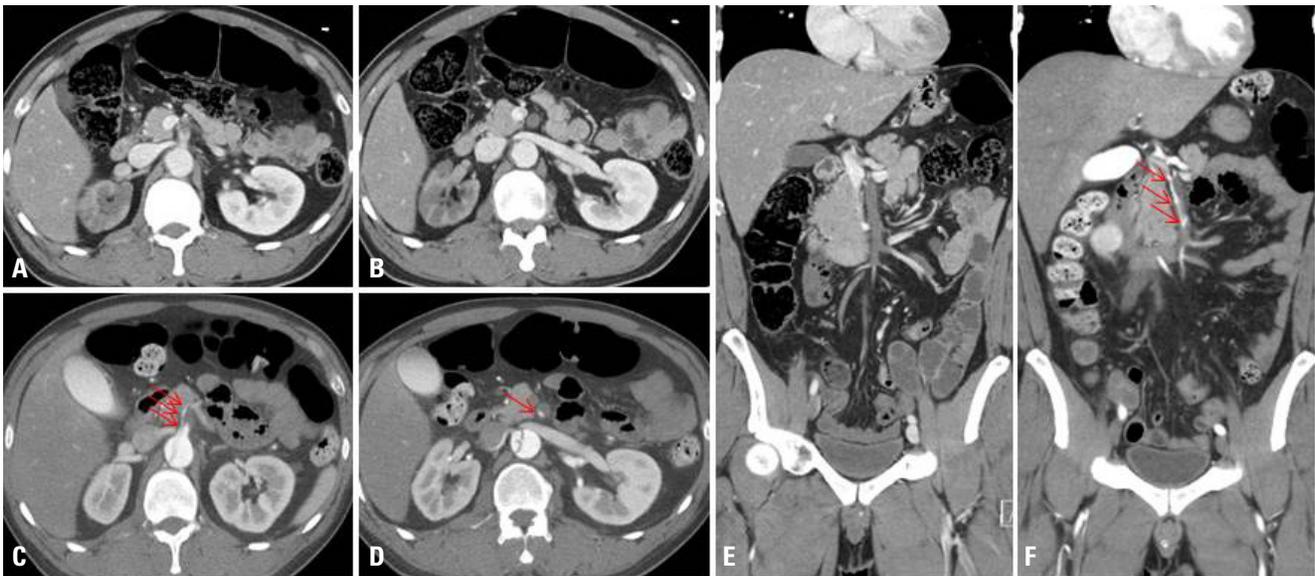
Change in superior mesenteric artery flow before and after the fenestration. (A, B, E) Initial CT before fenestration showing occluded superior mesenteric artery occluded 1 cm distal to its origin. (C, D, F) Follow up CT after fenestration, at day 5 shows narrow recanalized true lumen of superior mesenteric artery (arrows; images about the same level as A, B, E, respectively). CT: computed tomography.
